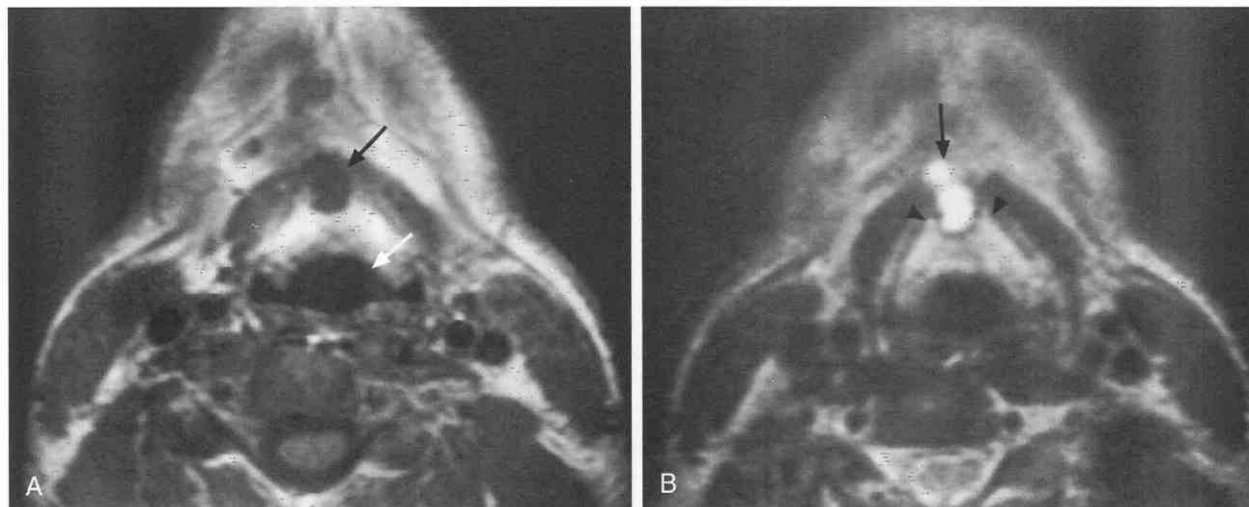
Thyroglossal duct cyst. *A*, Axial T1-weighted MR image just inferior to the hyoid bone shows a rounded, low-signal-intensity mass (*black arrow*) in the anterior pre-epiglottic fat at the superior margin of the thyroid cartilage. The normal epiglottis (*white arrow*) is demonstrated. *B*, Axial T2-weighted image slightly inferior to *A* shows the lesion (*arrow*) extending anterior to the thyroid cartilage (*arrowheads*) between the strap muscles. The lesion shows increased signal intensity on the T2-weighted sequence.
